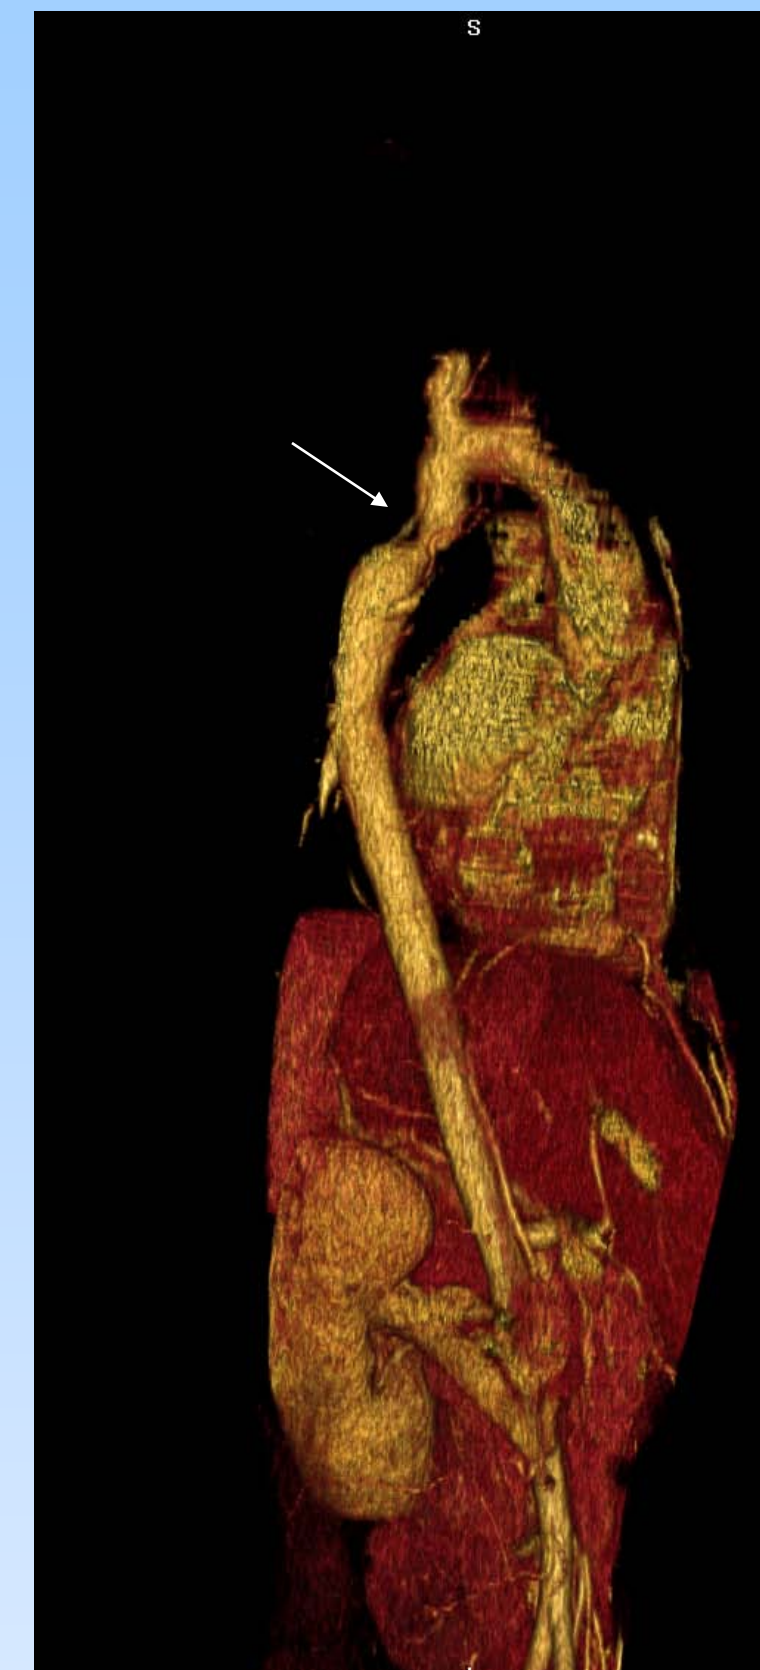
Posterior view of 3-D reconstruction of CTA demonstrating coarctation of aorta
